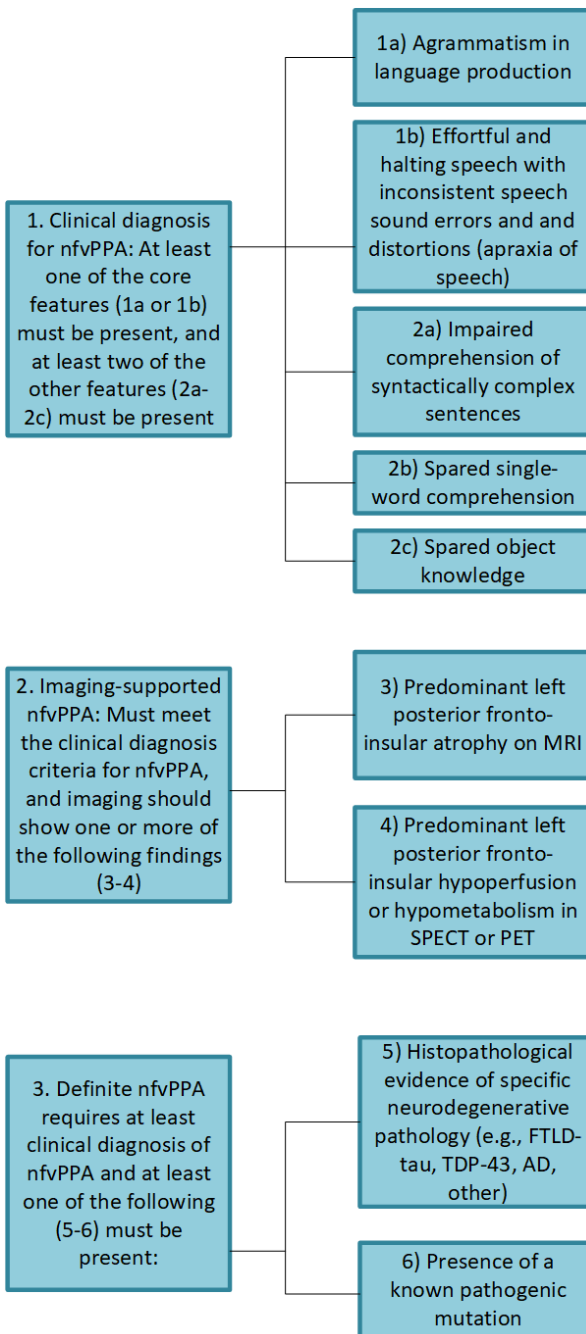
Diagnostic criteria for nfvPPA according to Gorno-Tempini et al. 2011. NfvPPA = non-fluent variant of primary progressive aphasia, MRI = magnetic resonance imaging, SPECT = single photon emission computed tomography, PET = positron emission tomography, FTLD = frontotemporal lobar degeneration, TDP-43 = TAR-DNA binding protein of 43 kDa, AD = Alzheimer`s disease.
